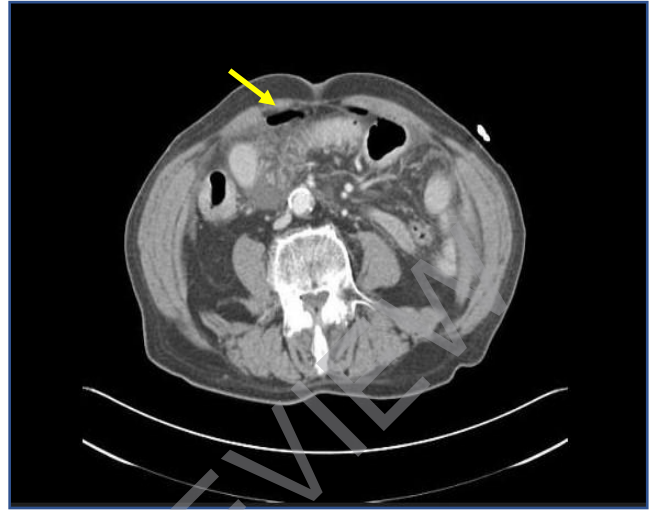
CT scan shows pneumoperitoneum and moderate amount of intraperitoneal free fluid reviled with small bowel perforation
